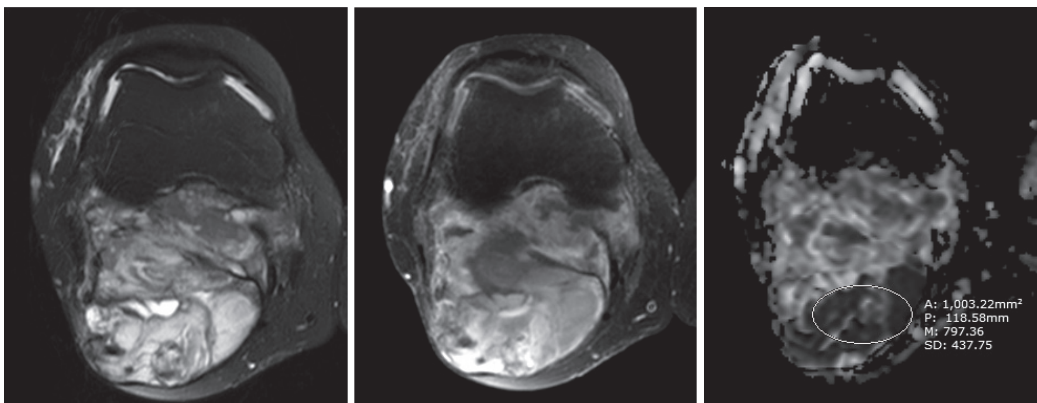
A 49-year-old woman with synovial sarcoma at right knee, A: Axial fat-suppressed T2-weighted image shows a heterogeneous mixed iso and hypersignal mass. B: Axial fat-suppressed contrast-enhanced T1-weighted image shows a heterogeneous enhancement of the mass. C: Axial ADC map shows low signal intensity of the restricted diffusion area in the mass. The ROI was placed over the tumor and was adjusted about one-fourth of the tumor size by avoiding the region of cystic or necrotic portions in the mass, with the ADC values of $0.797 \times 10^{-3} \text{ mm}^2/\text{s}$.
